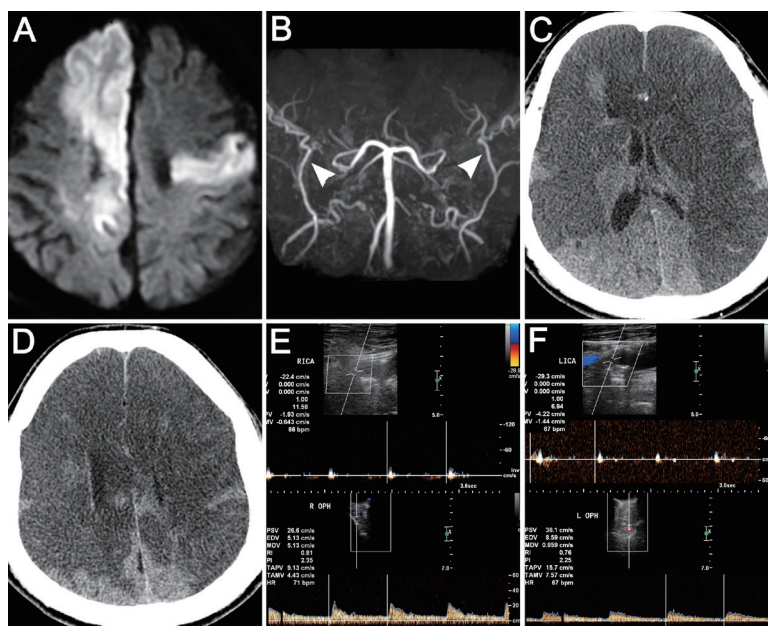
Imaging study results of patient 5 with acute bilateral carotid occlusion. (A) Axial view of diffusion-weighted MRI findings showed acute infarction involving the right high frontal and left frontal lobes. (B) MRA revealed absent bilateral ICAs with collateral flow from the bilateral external arteries (arrowheads) to bilateral MCAs. (C and D) Axial view of the brain CT findings on day 7 revealed acute infarction with diffuse edematous change involving both frontoparietotemporal lobes. (E and F) CDS on day 8 showed occlusion of the bilateral proximal ICAs (upper half) with forward bilateral OAF (lower half).
